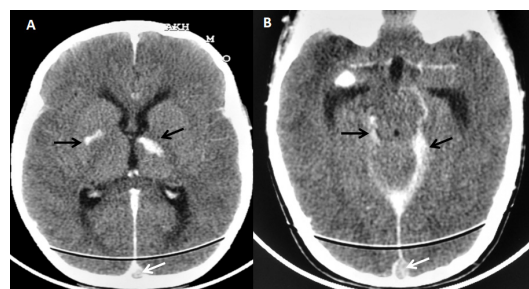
Contrast-enhanced CT of the brain. Axial sections (A, B) showing hyperdensities in right globus pallidus and left thalamus suggestive of acute haemorrhagic infarct (black arrow) (A) and basal exudates (black arrow) (B). There was a filling defect in superior sagittal sinus suggestive of thrombosis (A and B, white arrow).
